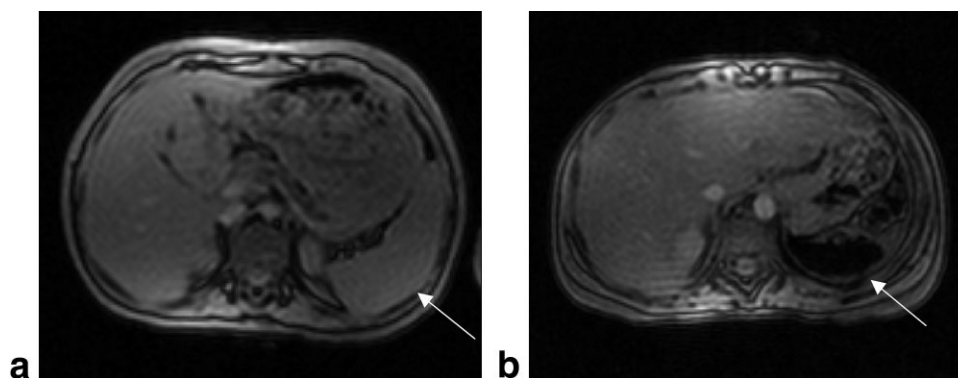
Example of (A) a normal spleen in a TM patient and (B) an infarcted spleen in an SCD patient. Because of iron concentration from volume loss, the iron levels of infarcted spleens were too high to be measured by MRI. Thirty SCD patients had infarcted spleens and thus had to be omitted from the present study.
